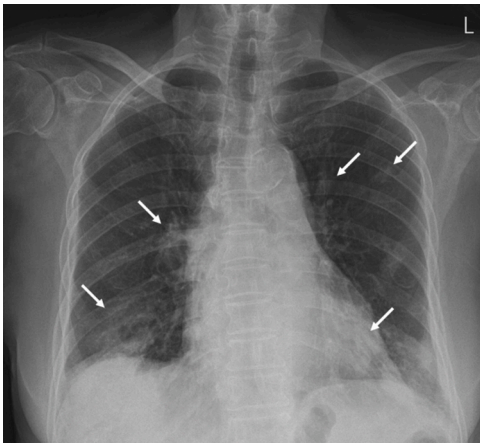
Initial posteroanterior chest radiograph performed at another hospital showing multifocal consolidations and ground-glass opacities in both mid and lower lung zones (arrows).
